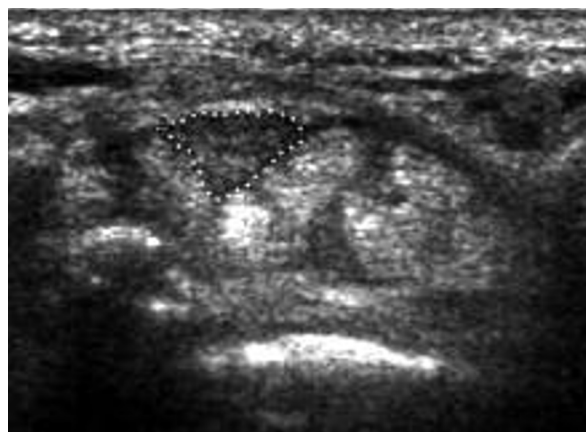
Carpal tunnel syndrome in a 46-year-old woman. Transverse 5-12 MHz sonographic scan shows triangular deformation of the enlarged (20 mm²) median nerve cross-section
